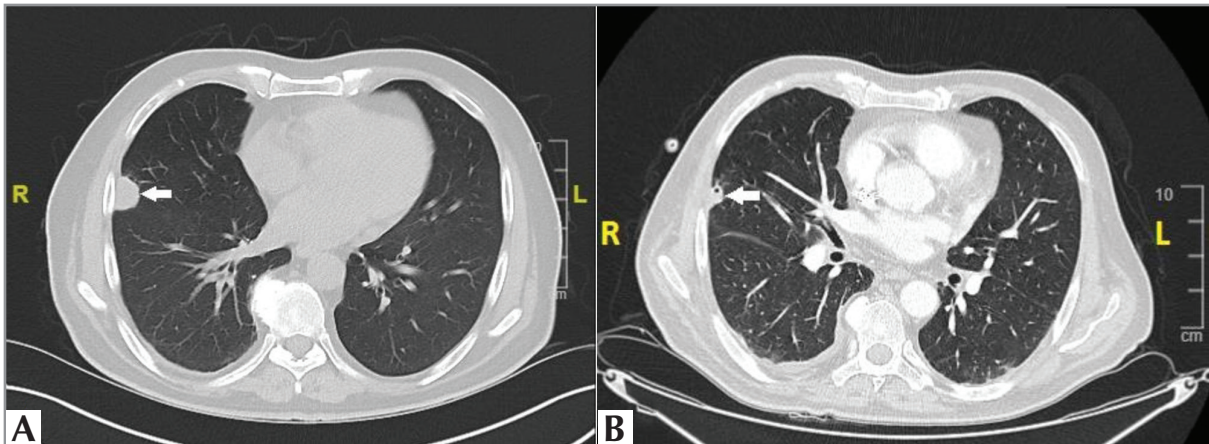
Thorax computed tomography demonstrating: A. A 17x19 mm soft tissue lesion in the lateral segment of the middle lobe of the right lung. B. A 10x13 mm lesion containing cavitation in the lateral segment of the middle lobe of the right lung, which has shrunk in the first month of antibiotic treatment, compared to previous imaging.
